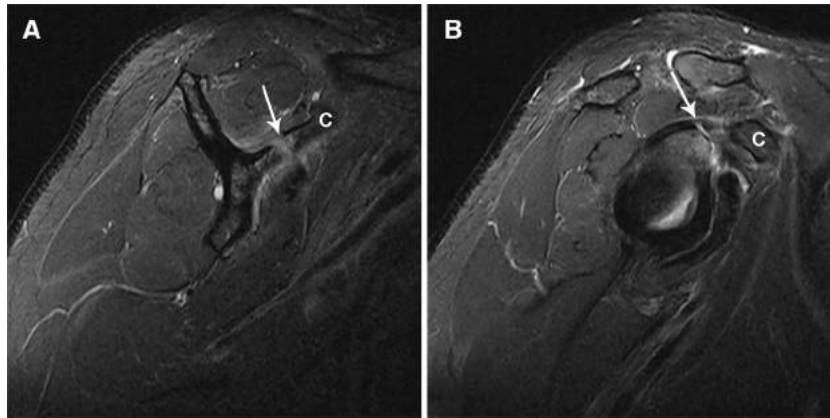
Magnetic resonance images of the patient's right shoulder showing the coracoid (C) fracture nonunion (*arrows*). These scans were obtained 1 year after the trauma.
